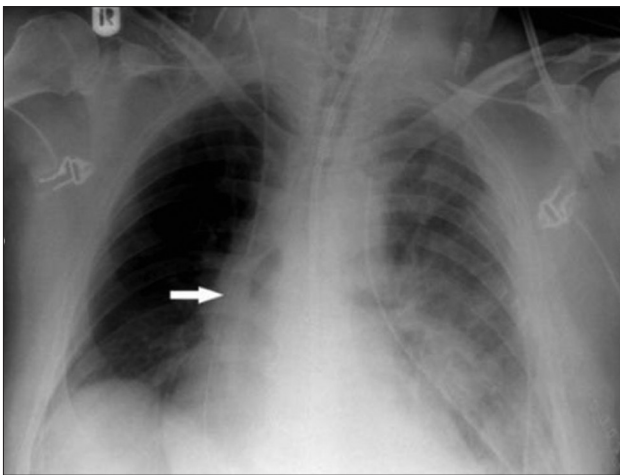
Guidewire (arrow) on bedside chest X-ray, below level of central venous catheter tip
